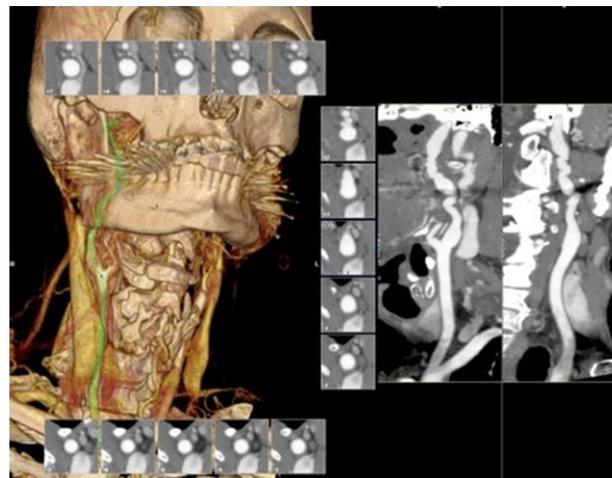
Computed tomographic angiogram showing multifocal fibromuscular dysplasia (FMD) of the right internal carotid artery. The patient also had multifocal FMD and an ophthalmic artery aneurysm on the left side (not shown).
